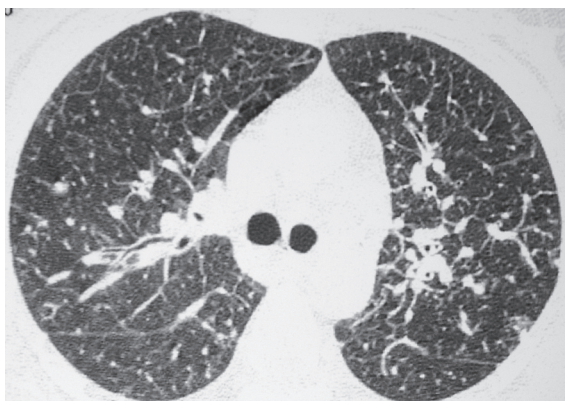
High-resolution computed tomography slice at the carina shows signs of thickening of the central lung interstitium and interlobular septa. Some small nodules with perilymphatic distribution are also observed.
